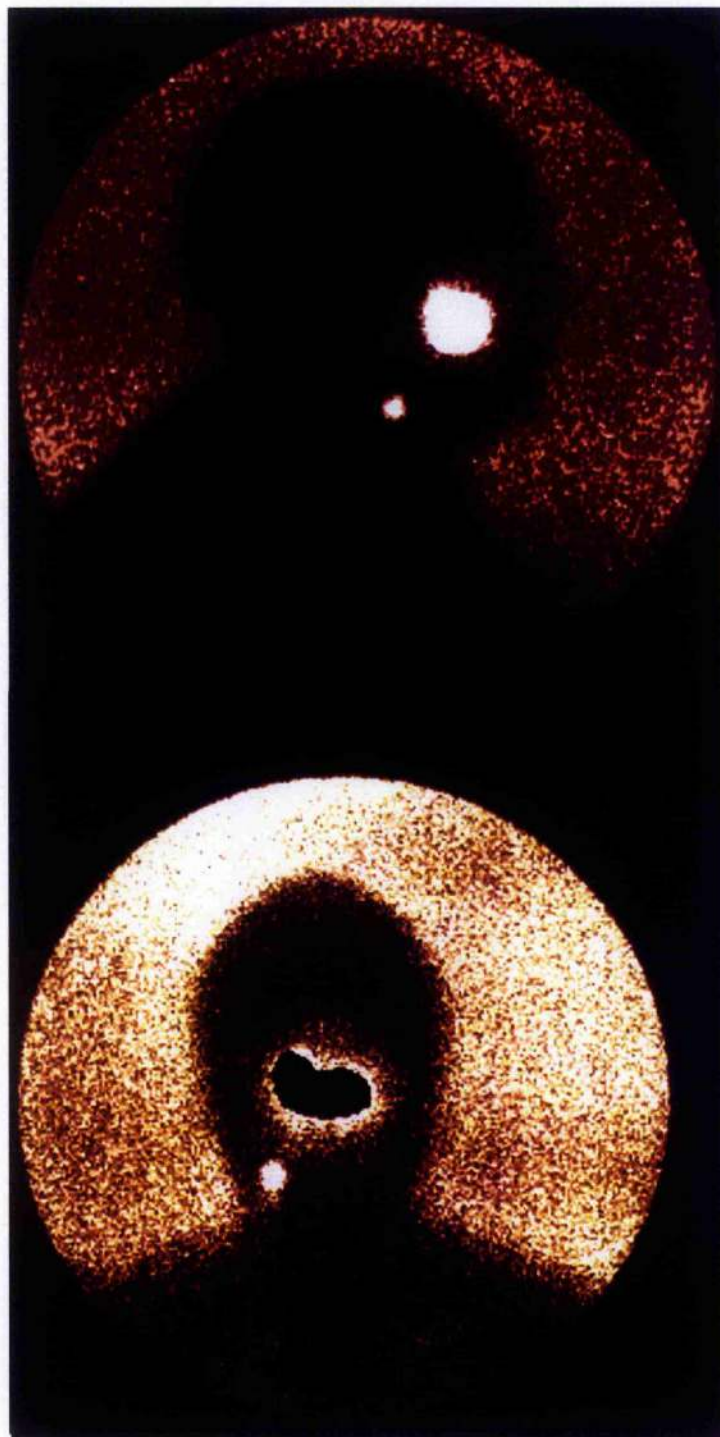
Lymphoscintigraphy of patient with palatal melanoma
